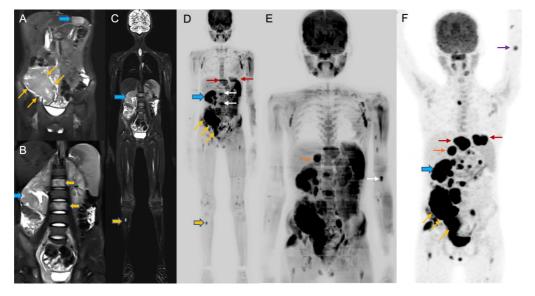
Stage IV on both WB-MRI and PET-CT. A. Coronal STIR image showing hyperintense thickening involving the terminal ileum, caecum and ascending colon (yellow arrows). A focal STIR hyperintense lesion is also seen in the left lobe of the liver (blue solid arrow). B. Coronal STIR image showing hyperintense lesion involving the right kidney (blue solid arrow) with mild hydronephrosis. STIR hyperintense lesions are also seen involving the L1 and L3 vertebrae (yellow solid arrows). C. Coronal STIR hyperintense focal lesion is seen involving the proximal shaft of the right tibia (yellow solid arrow). The image also shows a lesion in the right kidney (blue solid arrow). D & E. Coronal MIP DWI images showing diffusion-restricting lesions involving the terminal ileum, caecum, ascending colon (yellow arrows), right kidney (blue solid arrow), liver (red arrows) vertebral lesions (white arrows), right proximal tibia lesion (solid yellow arrow) right adrenal lesion (orange arrow in E) and left humerus lesion (white arrow in E). F. Coronal MIP PET image showing FDG avid lesions involving the terminal ileum, caecum, ascending colon (yellow arrows), right kidney (blue solid arrow), liver (red arrows), right adrenal lesion (orange arrow) and left humerus lesion (purple arrow). An additional lesion was seen in the right tibia on WB-MRI which was not covered in PET-CT, however, it did not change the stage of lymphoma.
